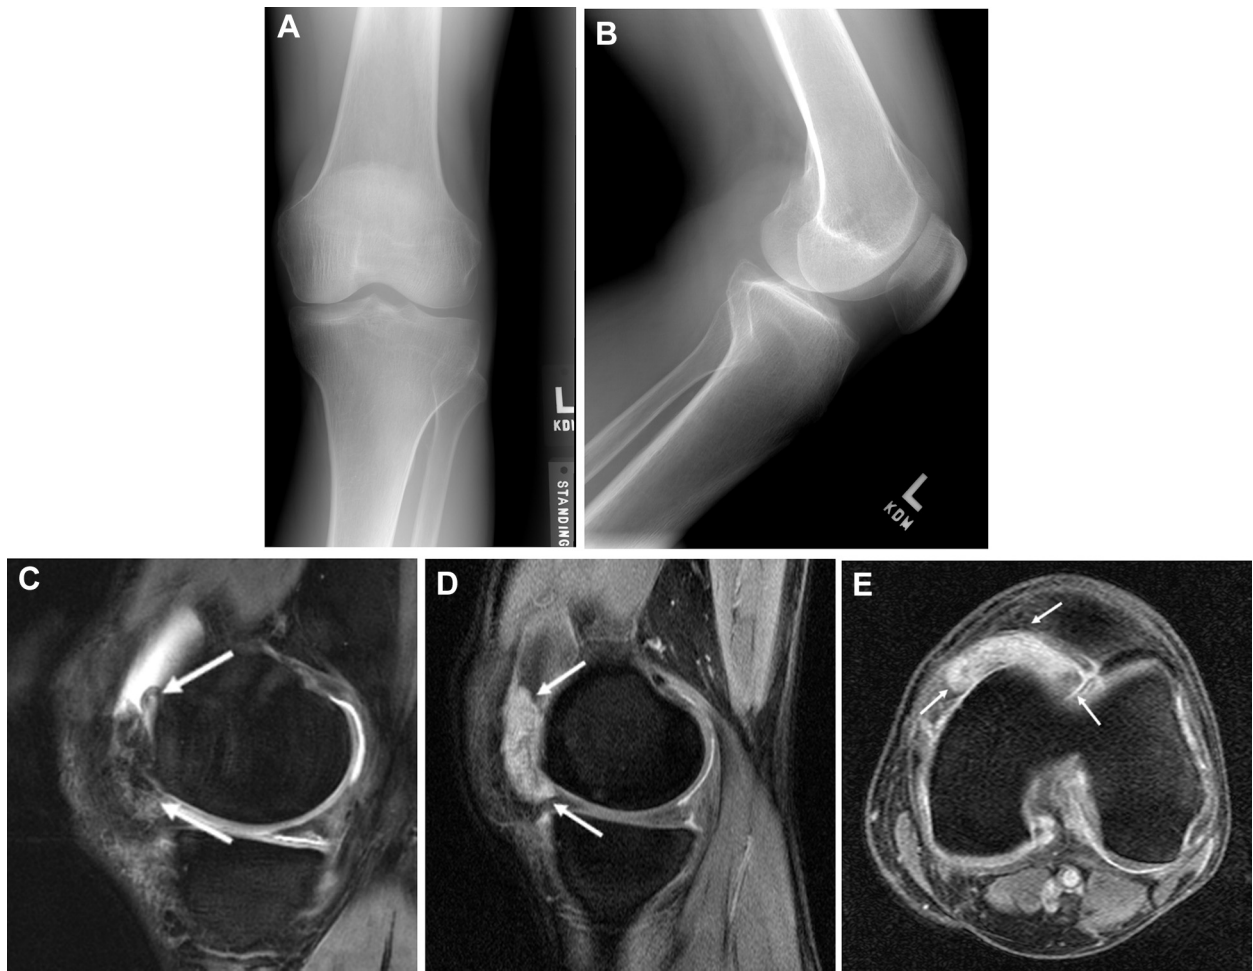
A 62-year-old man with bilateral pigmented villonodular synovitis of the knee. Frontal (A) and lateral (B) radiographs of the left knee demonstrate minimal patellofemoral osteophyte formation and small joint effusion. Sagittal T2 fat-saturated (C) and sagittal (D) and axial (E) postcontrast T1-weighted magnetic resonance images of the left knee reveal a lobulated, enhancing mass (arrows) in the anteromedial knee, which on excision was consistent with pigmented villonodular synovitis.
